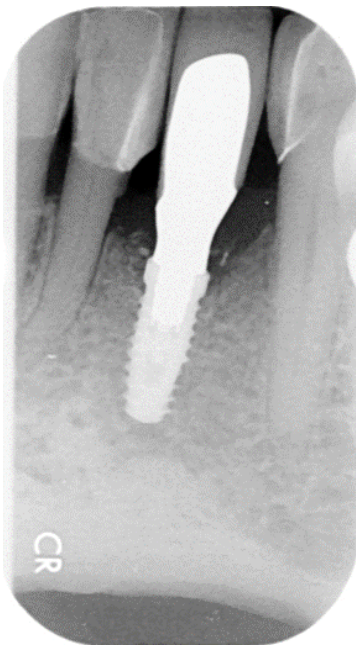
The pre-treatment picture are on the left and post treatment photos are on the right. The radiograph shows the implant bone levels after 3 years of loading. The bone level is excellent and patient is happy
